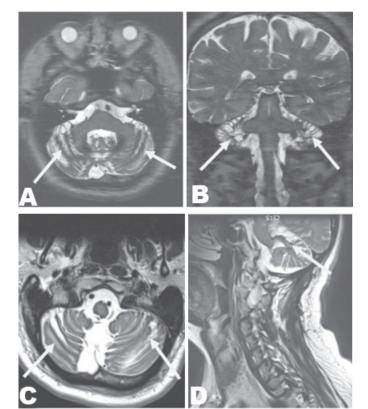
Showing black rimmed hypointensity of the cerebellum on T2 (A) axial and (B) Coronal MRI views. Showing no significant change in the area of black rimmed hypointensity postoperatively on T2 (C) Axial and (D) Sagittal views.
